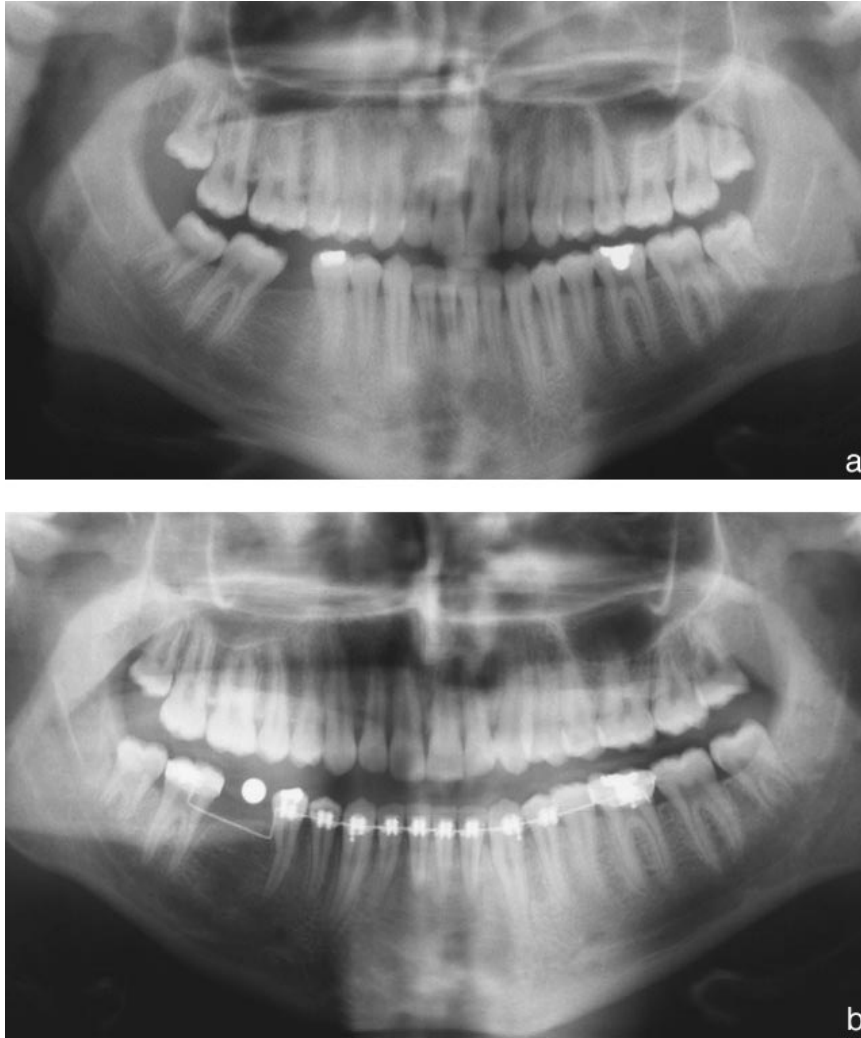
Panoramic radiography of Case 1. (a) Before orthodontic treatment and (b) after orthodontic treatment.
